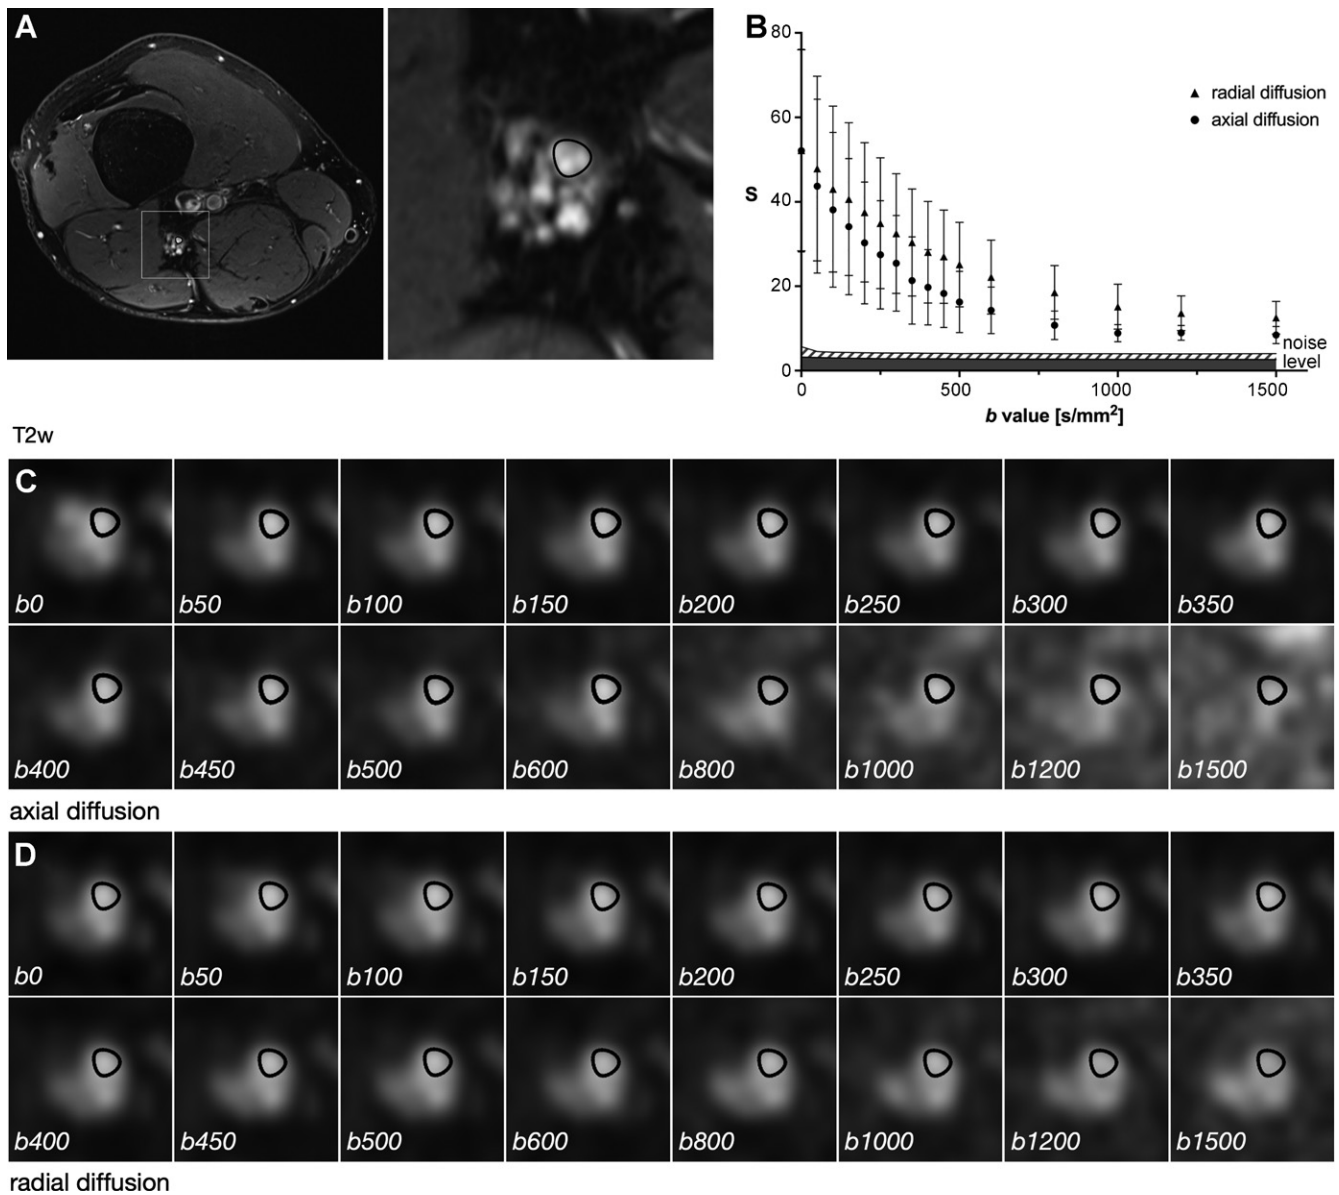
Diffusion-weighted imaging nerve lesions in participants with diabetes. (A) T2-weighted (T2w) images and series of diffusion-weighted images at 16 b values acquired in (C) axial and (D) radial diffusional domains in the T2-pathologic nerve part of a representative patient with diabetes (participant 2 in Table 1). Segmentation of the tibial nerve is indicated by a black contour. (B) Inserted graph depicts the diffusion-weighted signal (S) measured within the region of interest (ROI) of the nerve as a function of b in participants with diabetes (arbitrary units). Error bars represent 95% CIs. Noise levels within a standardized region of interest are also shown with 95% CIs (light and dark gray shaded areas). Signal in ROI of the nerve remains well above noise level in both radial and axial directions over the entire range of b values. In C and D, the window level of each magnified image is set to a linear gray scale from 0 to twice the magnitude signal of each ROI of the nerve.
